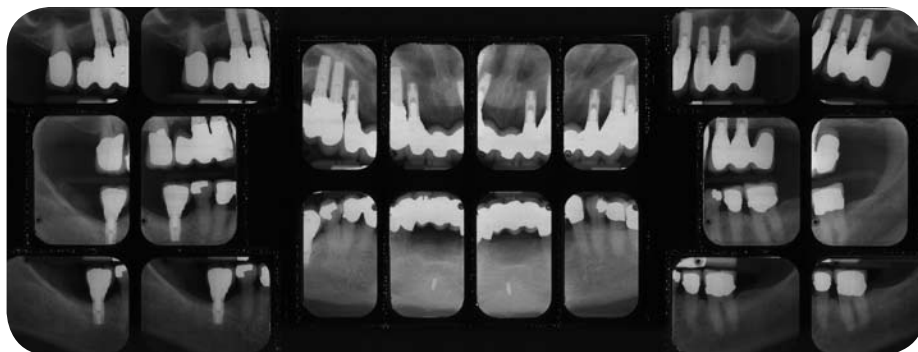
Radiographs of patient in Figure 5 after maxillary reconstruction with dental implant supported restorations (Courtesy of Dr. Mordohai).
